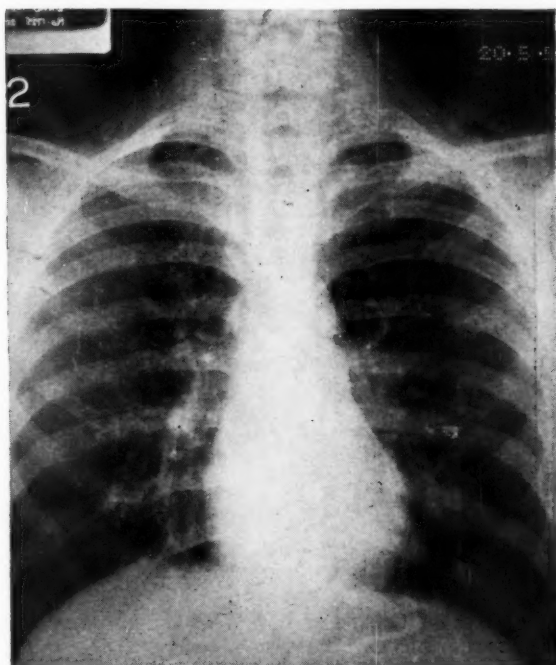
Radiograph showing double contour of the left border of the heart and subcutaneous emphysema of the neck.
